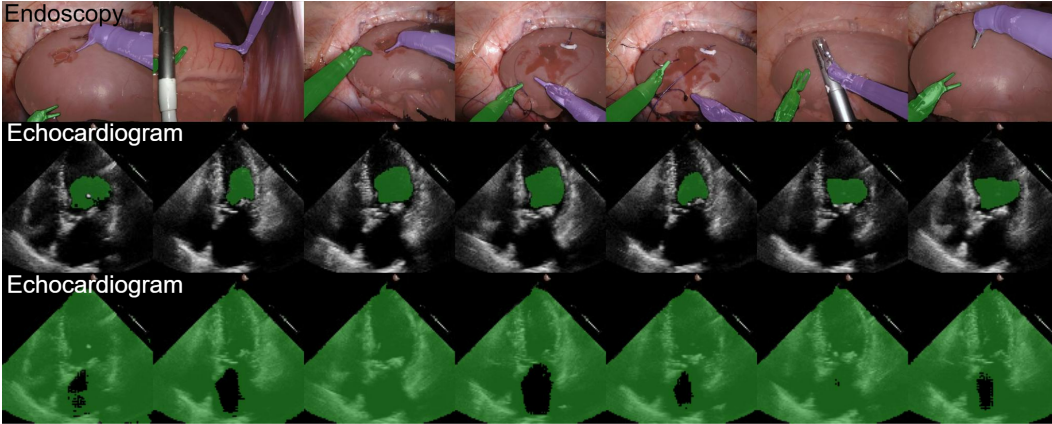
The visualization results of SAM-2 on two medical scenarios. The last row is the failure example of SAM-2 in 1-click application on low-resolution ultrasound videos.
